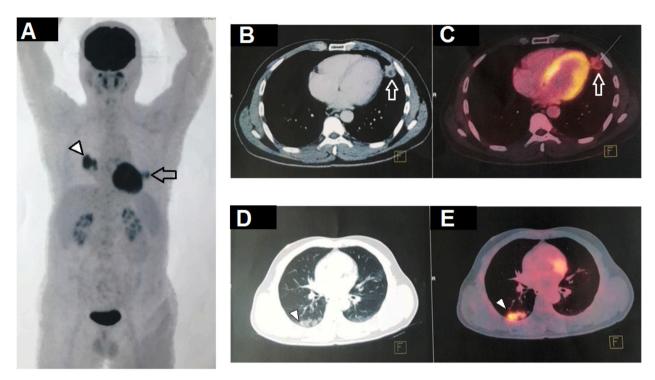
(A) PET-CT maximum intensity projection (MIP) image showed lessons in the left chest (arrow) and right chest (arrowhead). (B) Chest CT image and (C) fluorodeoxyglucose (FDG) PET image showed a nodule in the left lung, with a maximum SUV of 4.81 (arrow). (C) Chest CT image and (D) FDG-PET image showed ground-glass opacity area in the right lung with a maximum SUV of 10.12 (arrowhead).
